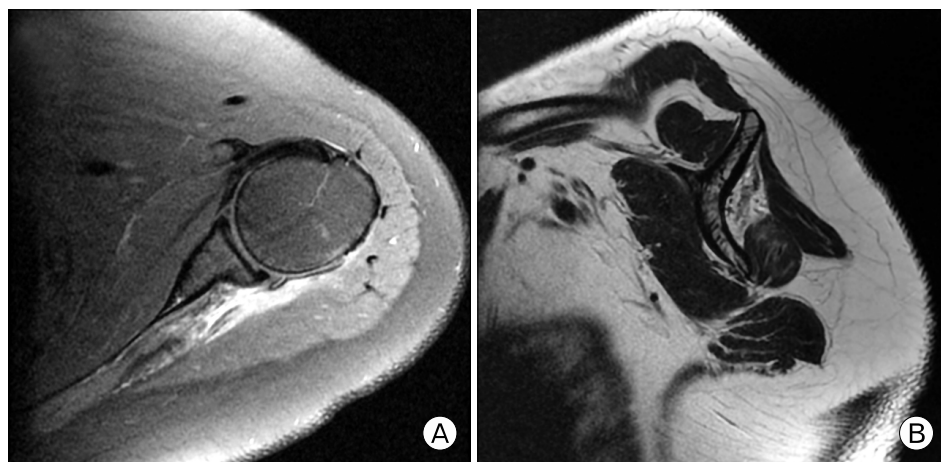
(A) Magnetic resonance imaging showed that the distal region of the infraspinatus tendon had a full-thickness tear, while the proximal region was retracted medially past the glenoid cavity with fatty atrophy. (B) An incomplete full-thickness tear of the teres minor muscle was also present.
